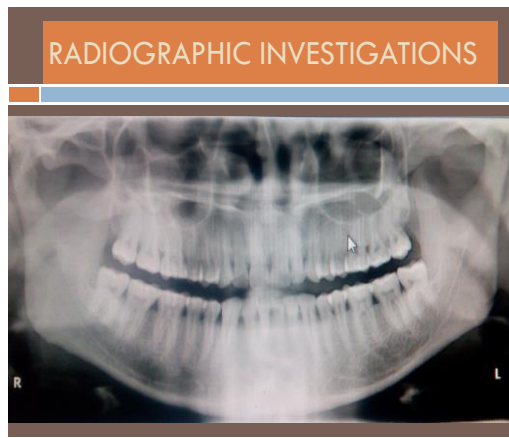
OPG (ORTHOPANTOMOGRAM)
